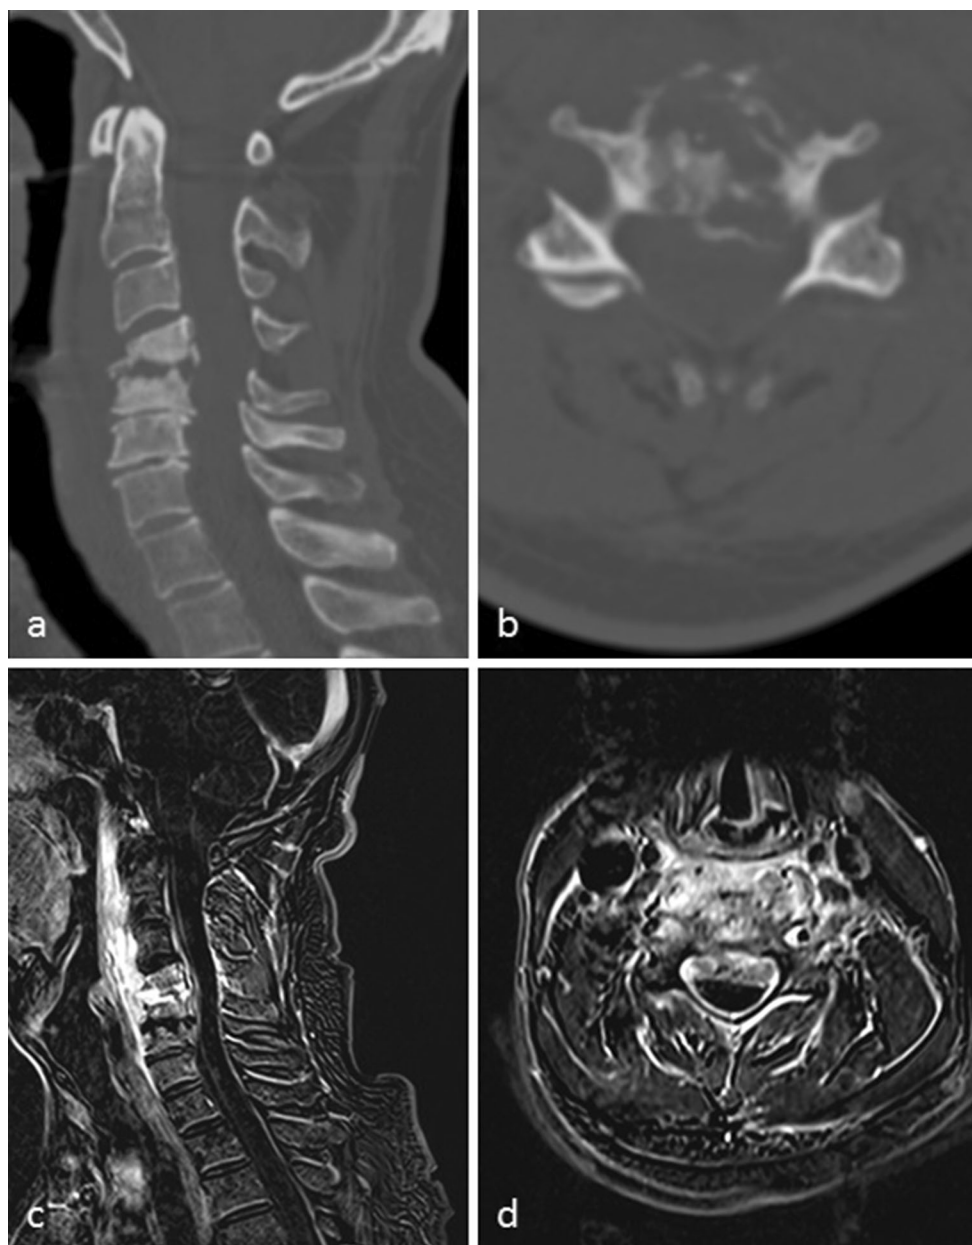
Preoperative CT scan in sagittal (a), axial (b) planes as well as MR-imaging in sagittal (c), axial (d) planes showing a spinal stenosis with destruction of C4–C6
